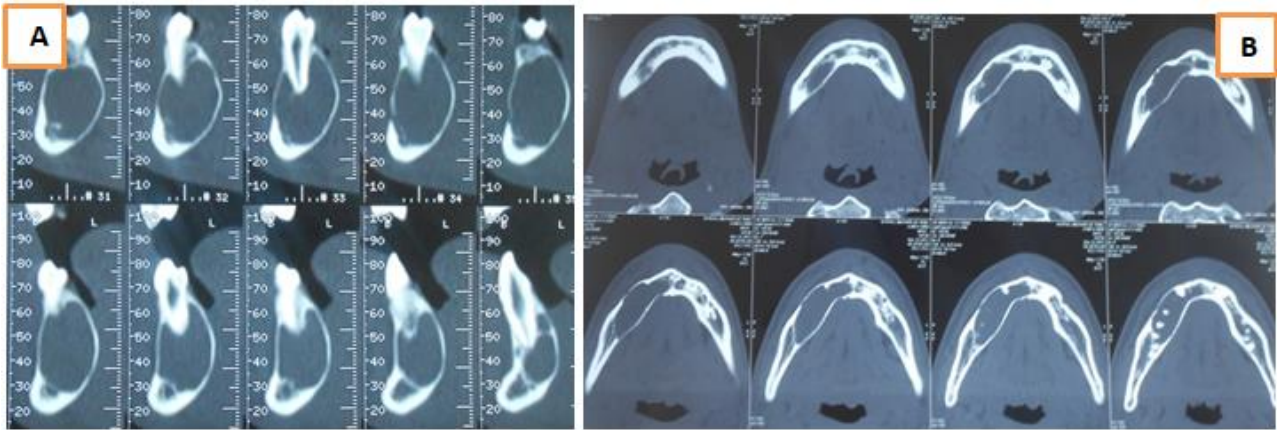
Patient 1: Mandibular CT scan showing integrity of the bony cortices and repression of the mandibular canal. A: oblique coronal sections, B: Axial sections
